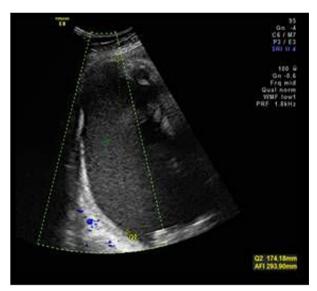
Ultrasound image showing polyhydramnios.
